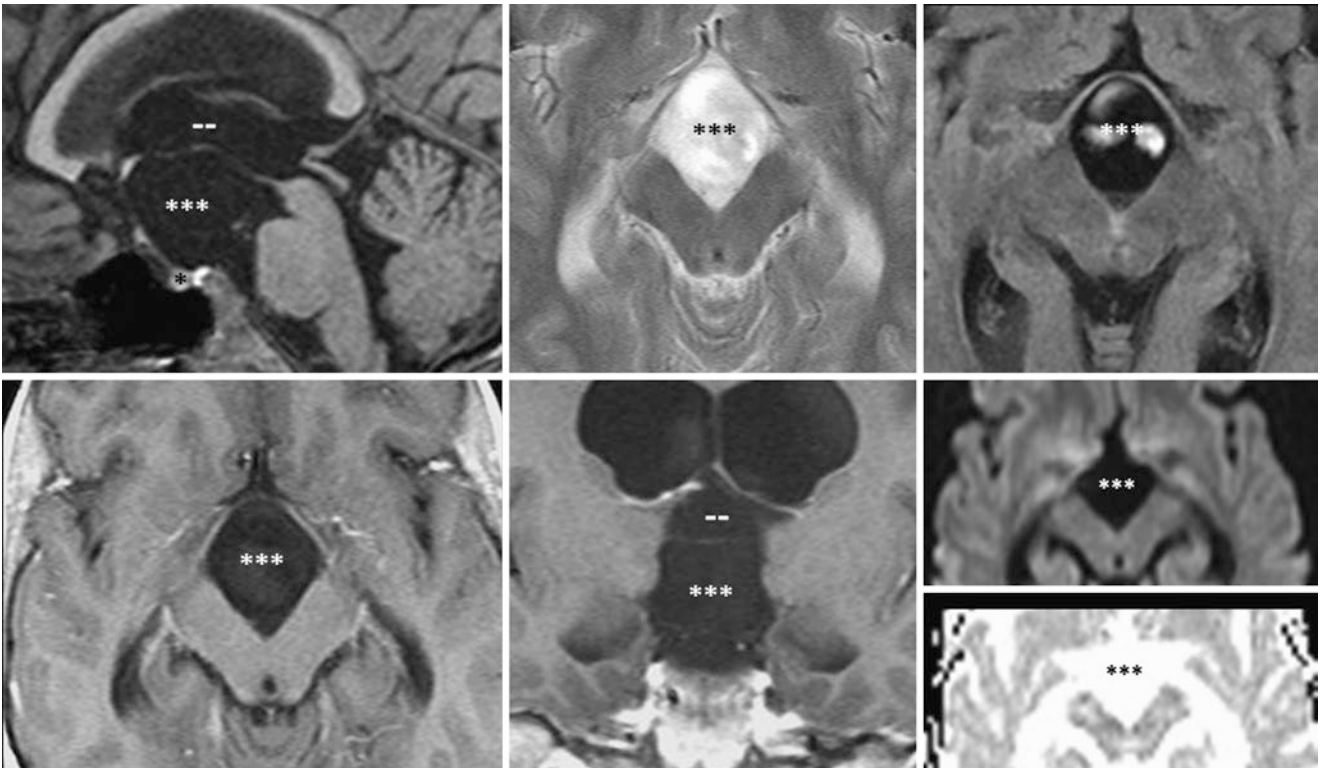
Comparison case of suprasellar arachnoid cyst. A 43-year-old male with hydrocephalus and an enlarged suprasellar cistern (*) as compared to the sella (*) on 3 T MRI noncontrast sagittal T1WI (*top left*), axial T2WI (*top middle*), FLAIR (*top right*), and postcontrast
